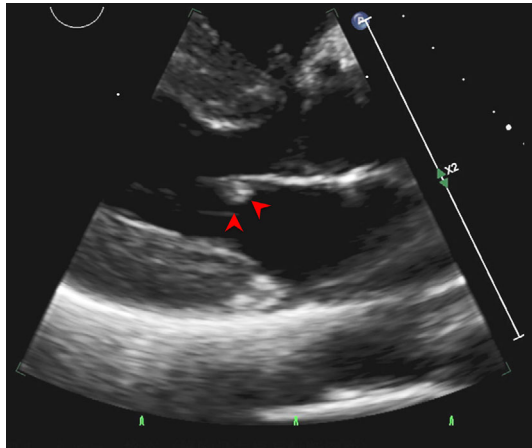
Transthoracic echocardiogram. Image shows 6×7-mm vegetation (arrowheads) on the anterior mitral leaflet.
